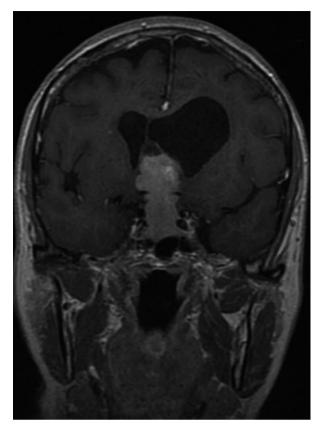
MRI image of pituitary gland tumour with asymmetric, contralateral parkinsonian syndrome
